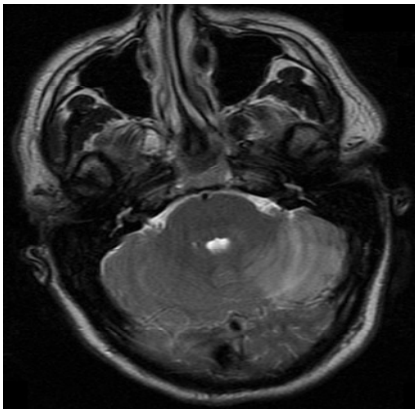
A T2 weighted MRI indicated an acute ischemic infarct involving the left superior cerebellum in the region of the left superior cerebellar artery.
